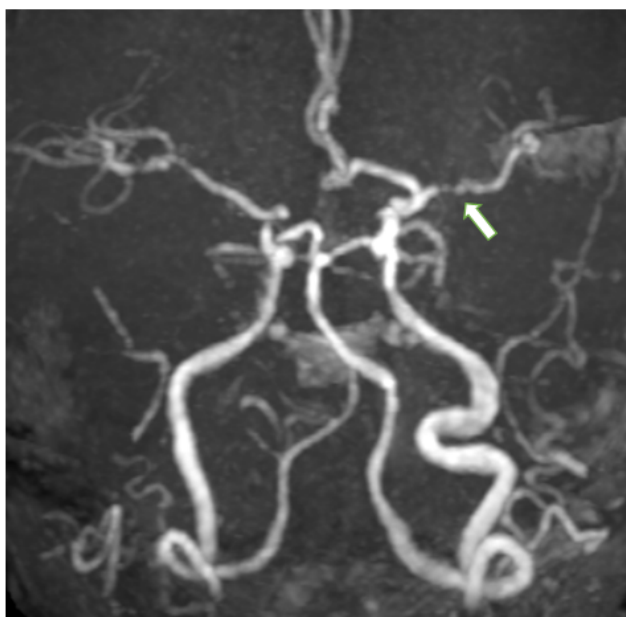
Old brain MRI demonstrated pre-existing left MCA middle segment 80% stenosis and right ACA A1 segment hypoplasia (white arrow).
